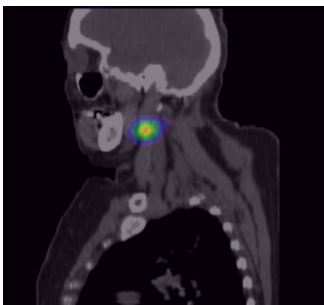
Case No. 1: lymphoscintigraphy, positive sentinel lymph node.
